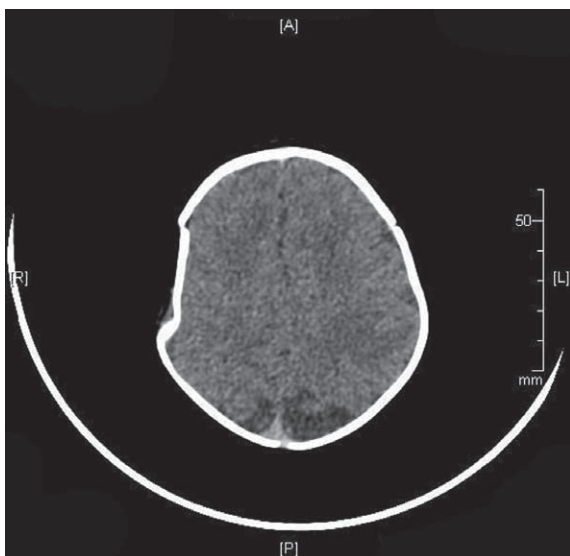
Conventional CT before the operation.
